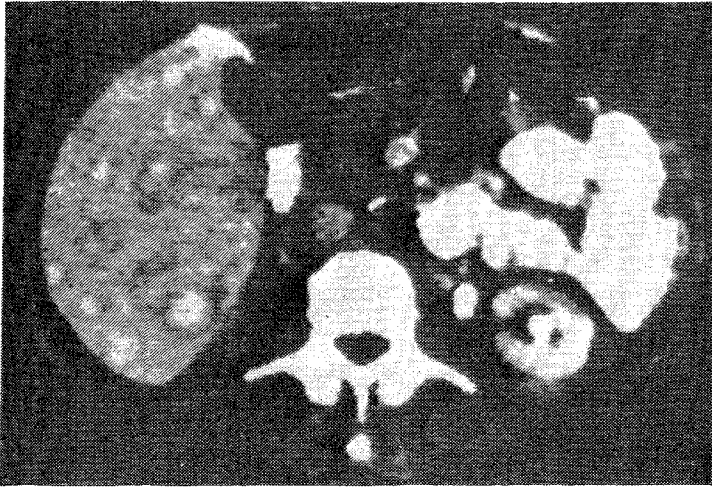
CT scan appearances before (upper) and after (lower) SMS 201–995 treatment.
